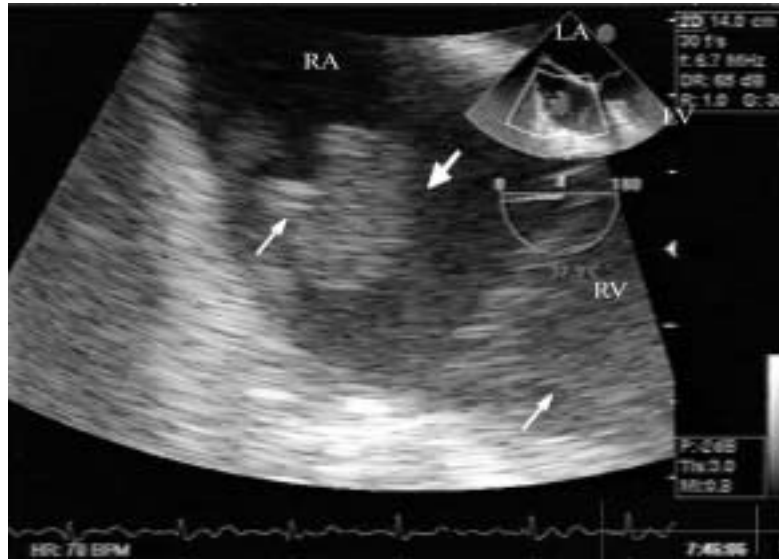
Transesophageal echocardiographic image: large thrombus (thick arrow) attached to the atrial portion of the pacemaker lead (thin arrow). LA = left atrium; RA = right atrium; LV = left ventricle; RV = right ventricle.
